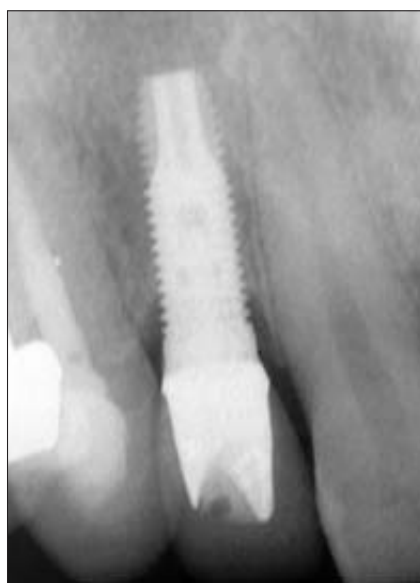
Radiograph of implant and final restoration.
